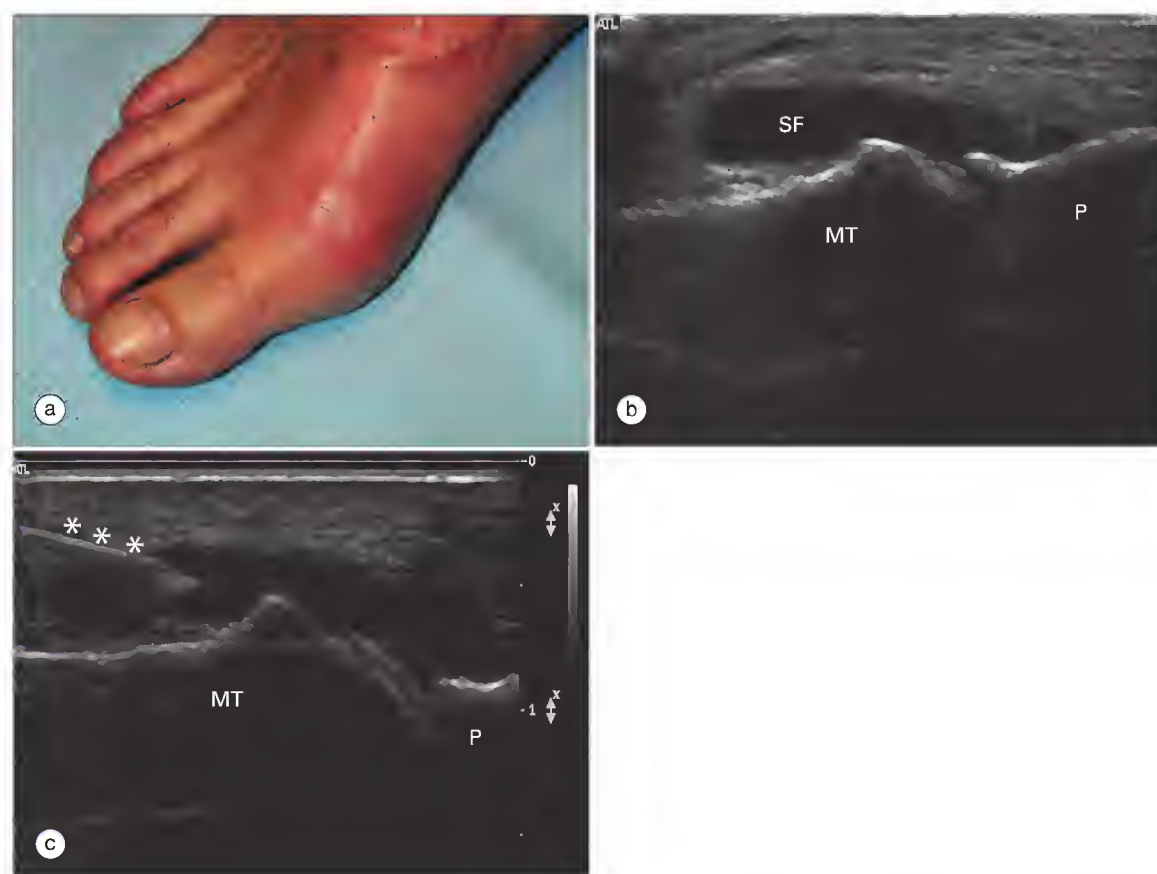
Inflammation of the first metatarsophalangeal joint, presumed to be gout. (a) This patient had acute swelling of the big toe with pain and erythema. The diagnosis of gout was suspected, but the serum urate level was within normal limits. (b and c) These longitudinal images through the toe demonstrate a hypoechoic collection in the joint that was compressible and displaceable and consistent with an effusion. A needle (asterisks) was subsequently introduced into the joint under ultrasound guidance and withdrew a small amount of fluid. Analysis confirmed the presence of urate crystals. MT, metatarsal head; P, phalanx; SF, synovial fluid.
